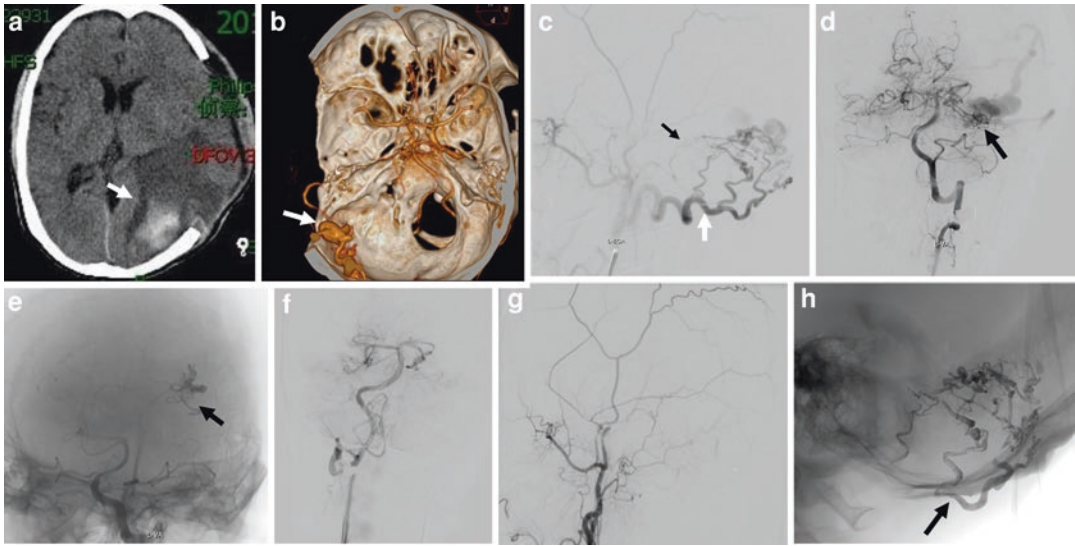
A 63-year-old male patient presented with intracerebral hematoma. (a) CT scanning showing hematoma in left occipital lobe treated by surgery and decompression treatment (arrow). (b) CT angiography showing a giant venous ectasia of the left occipital lobe (arrow). (c) The left external carotid artery angiogram (lateral view) showing a Zipfel type 3 dural fistula supplied by the dural branches of the ascending pharyngeal artery (black arrow) and the occipital artery (white arrow). (d) The left vertebral artery angiogram (frontal view) showing the dural fistula supplied by the temporal branches of the left posterior cerebral artery (arrow). The dural fistula was drained
